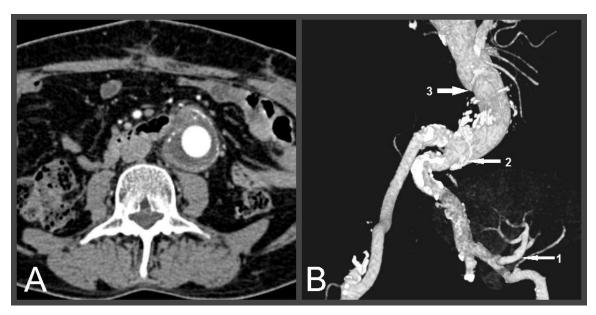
Postoperative computed tomographic angiography. A. Axial view. B. 3D-reconstruction: A patent renal artery (1); Distal anastomosis (2); Proximal anastomosis (3)
